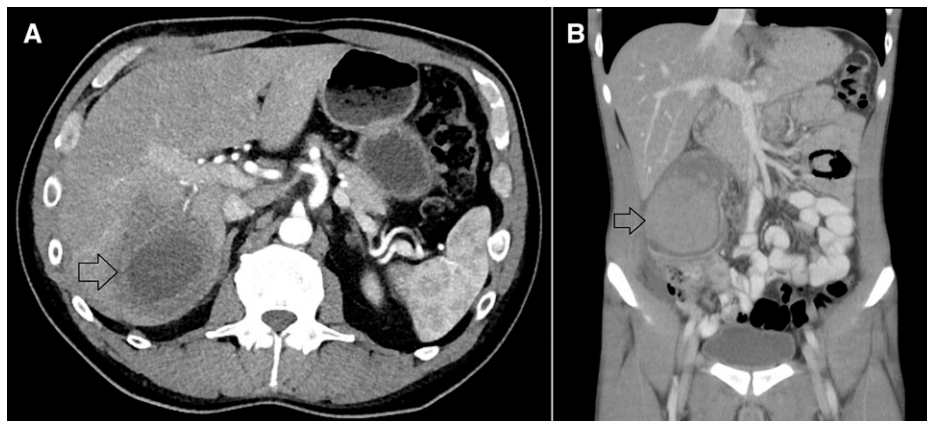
(A) Axial computerized tomography (CT) images show a large amebic liver abscess. (B) Coronal CT images reveal a large inflammatory mass adjacent to the appendix.
